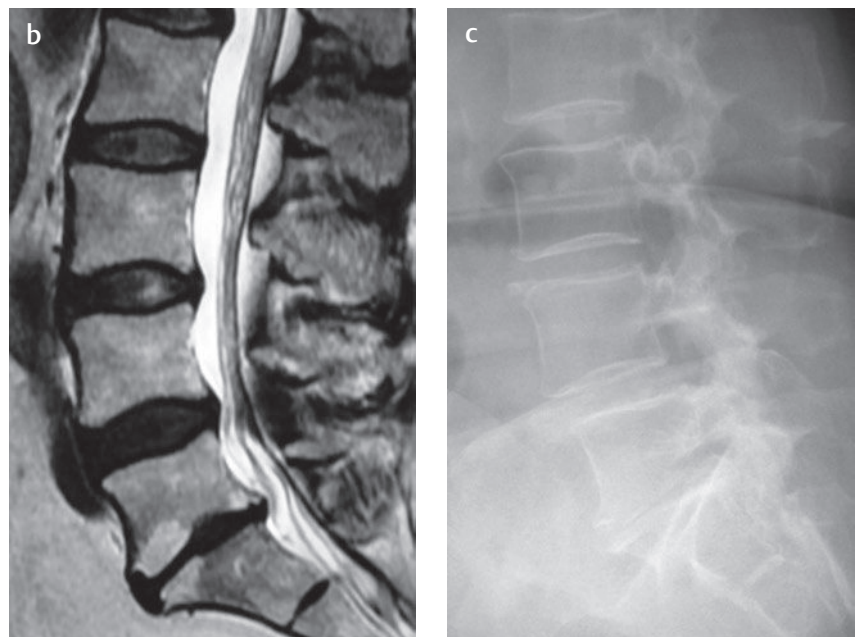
Facet arthropathy and dynamic instability. (a) An axial T2-weighted image at the L4-L5 level shows bilateral facet arthropathy with fluid within and distending the L4-L5 facet joints (arrows). (b) A sagittal T2-weighted image (obtained with the patient in a supine position) shows evidence of stenosis at this level and also suggests the possibility of a subtle L4-L5 spondylolisthesis. Advanced degenerative disc disease is also seen at the L5-S1 level. (c) A standing lateral radiograph shows an obvious Meyerding grade-1 spondylolisthesis at the L4-L5 level. This series of images shows that degenerative changes and excessive fluid within the facet joints may be associated with instability; given that MRI is performed with the patient in the supine position, the spondylolisthesis may not be seen on the sagittal MR images.[†]
